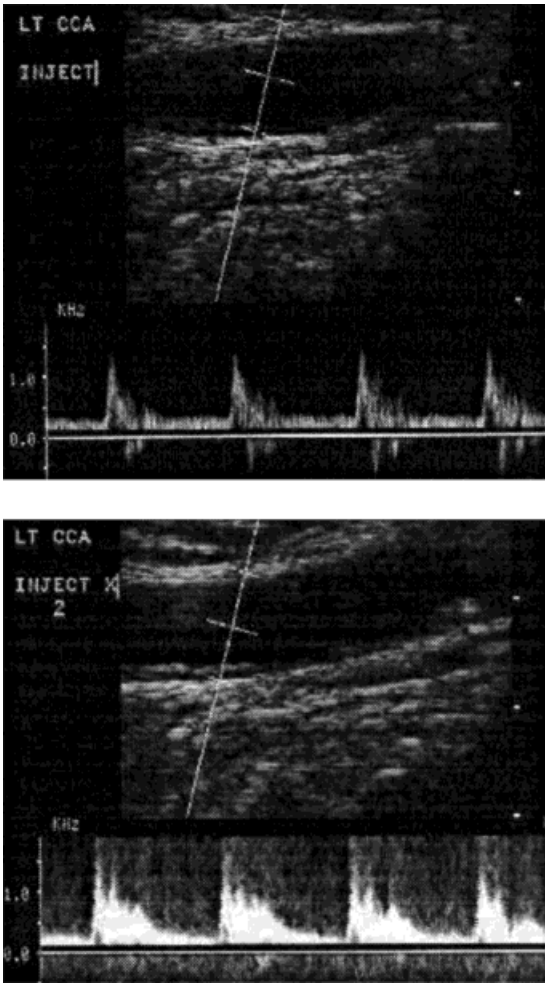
Spectral Doppler ultrasound of the common carotid artery pre (top) and post (bottom) microbubbles shows the characteristic increase in spectral Doppler signal upon arrival of the bolus.
